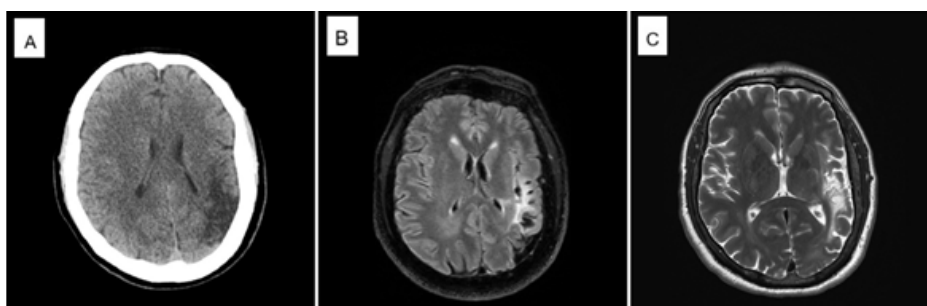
(A) Axial non-contrast brain CT showing a left parietotemporal cortico-subcortical encephaloclastic lesion, associated with left hemispheric volume loss and mild ipsilateral ventricular dilatation. (B) Axial FLAIR MRI demonstrating marginal gliosis associated with the left parietotemporal volume loss. (C) Axial T2-weighted MRI confirming left hemispheric atrophy with associated sulcal widening, ventricular enlargement and mild ipsilateral calvarial thickening.
